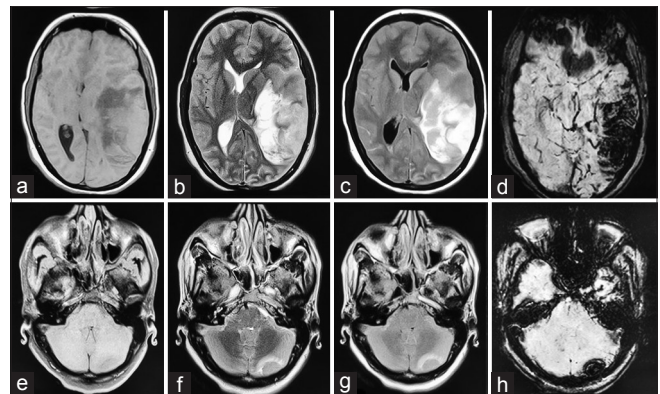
Axial magnetic resonance imaging of the brain showing (a) a large area of altered mixed signal intensity involving left fronto-temporo-parietal region causing mass effect in form of effacement of surrounding sulcal spaces, compression of ipsilateral lateral ventricle and mid line shift of 1.7 cm to the right. (b) The lesion was iso- to hyper-intense on T1-weighted and T2-weighted images. (c) Extensive surrounding edema (fluid ATTENUATED inversion recovery image). (d) Blooming on susceptibility-weighted imaging, but no postcontrast enhancement (not shown). (e-h) Similar morphology small lesions were noted in left cerebellar and left frontal parasagittal region (not shown)
